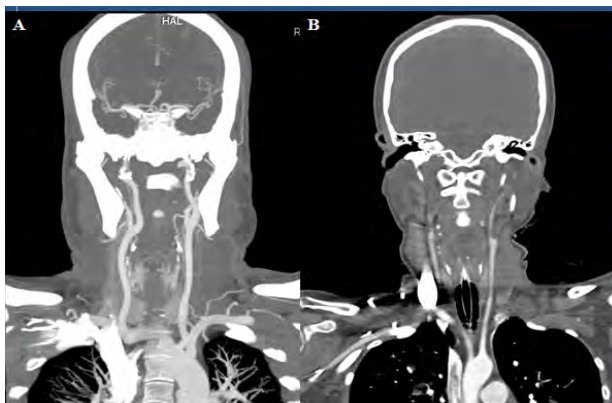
CT angiography showing normal opacification of extracranial and intracranial vessels (A) and non visualisation of intracranial circulation in a brain dead patient (B)
